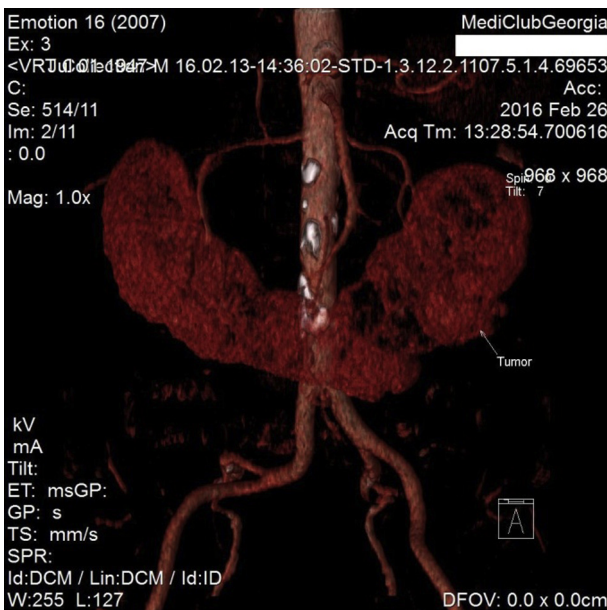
CT scan with three-dimensional reconstruction.
